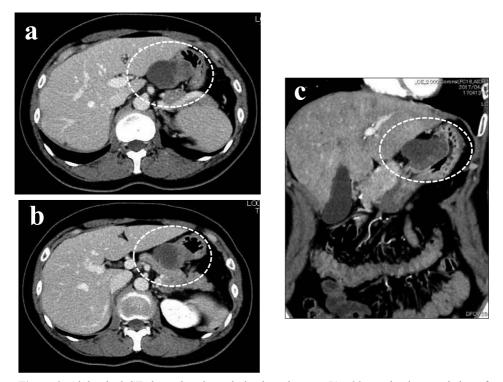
Abdominal CT showed an irregularly-shaped tumor 51×32 mm in size consisting of a well-enhanced component and a cystic component demonstrating no enhancement in the lower body and lesser curvature of the stomach. Transitional (a, b) and coronary (c) sections are shown.
